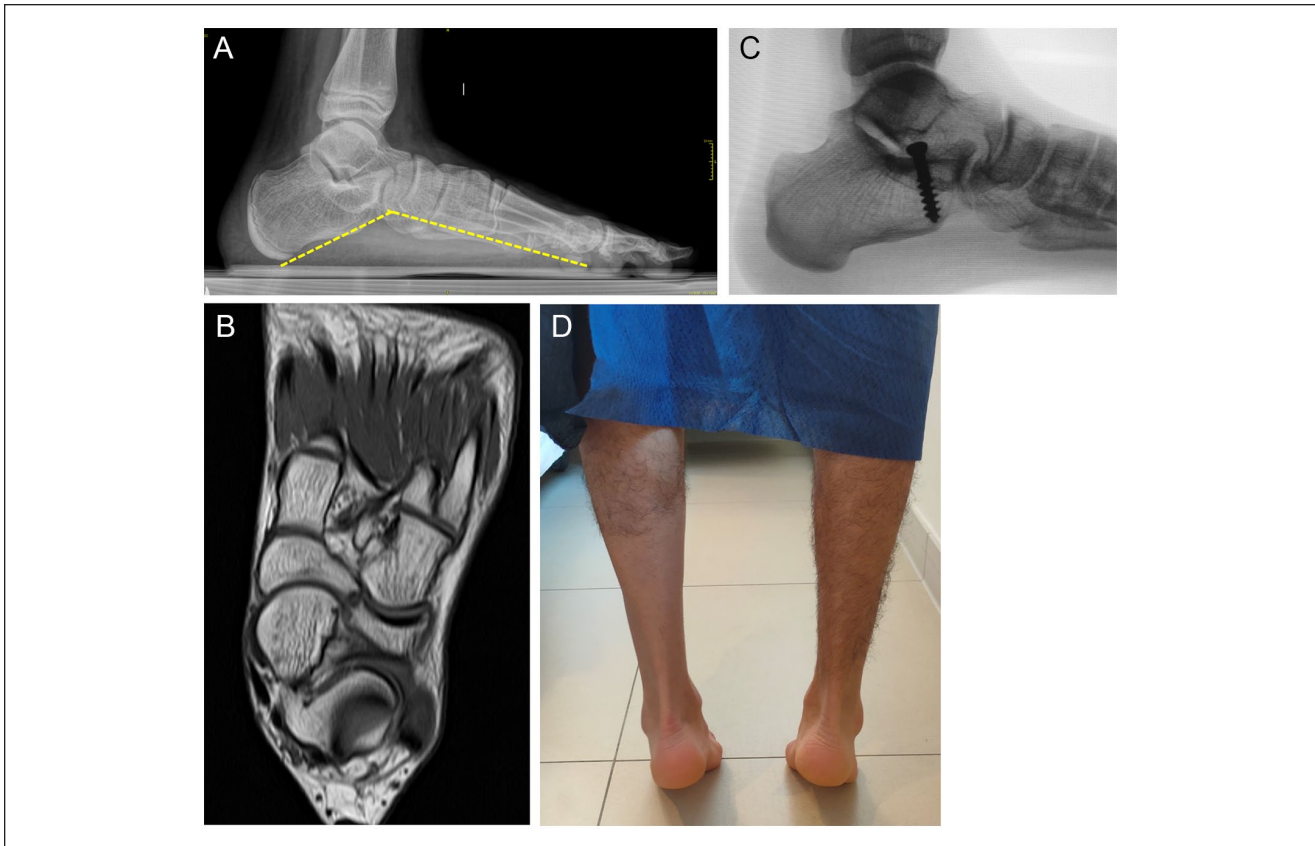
Fourteen-year-old boy affected by symptomatic rigid flatfoot deformity in calcaneonavicular coalition (CNC) of the left foot. (A) Preoperative weightbearing lateral view radiograph with talocalcaneal angle according to Costa Bartani (dashed lines) measuring 136 degrees. (B) Preoperative T1-weighted magnetic resonance imaging showing fibrocartilaginous tissue between the calcaneal and navicular bony border. (C) Radiograph at 6-year follow-up after coalition resection and subtalar extraarticular screw arthroereisis (SESA) procedure for correction of the residual valgus deformity. Proper screw position with normal talocalcaneal angle. (D) Functional outcome in tiptoes with normal pain-free range of motion; right foot for comparison.
